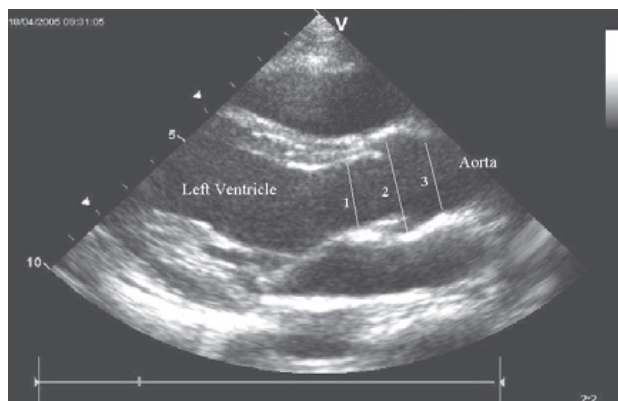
Echocardiographic measurement sites: 1. Aortic valve annulus, 2. Sinuses of Valsalva, 3. Sinotubular junction, parasternal long axis.
